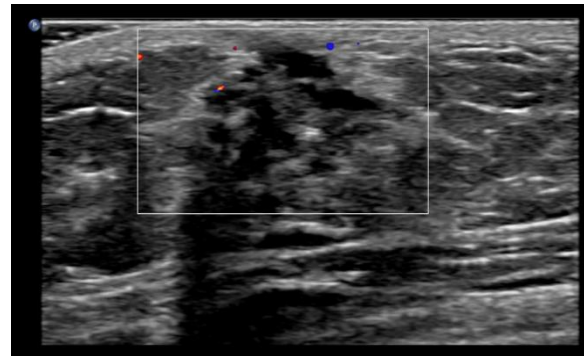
Right breast ultrasound showing intraductal lesion.
